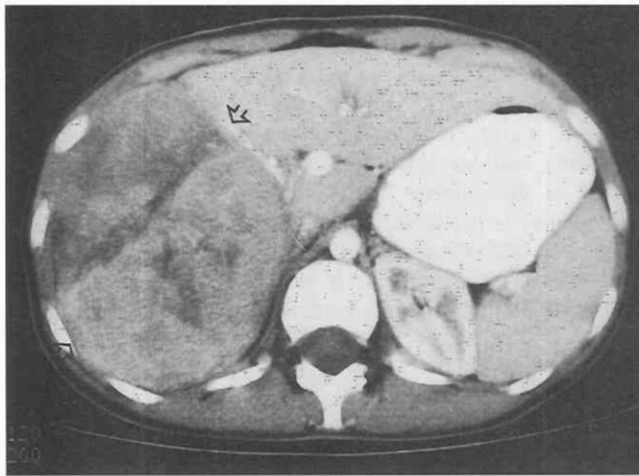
Hepatocellular carcinoma. CT of a large unifocal hepatocellular carcinoma shows a large heterogeneous low-attenuation mass (*open arrows*) in the right lobe of the liver.
